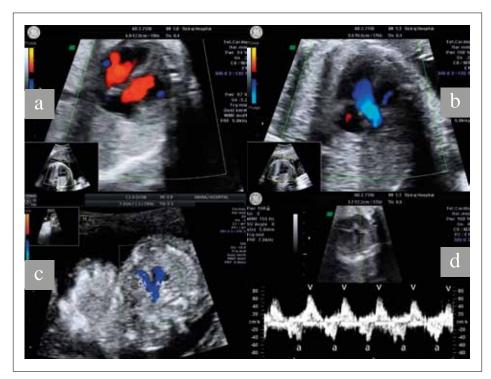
Normal Doppler ultrasound.
